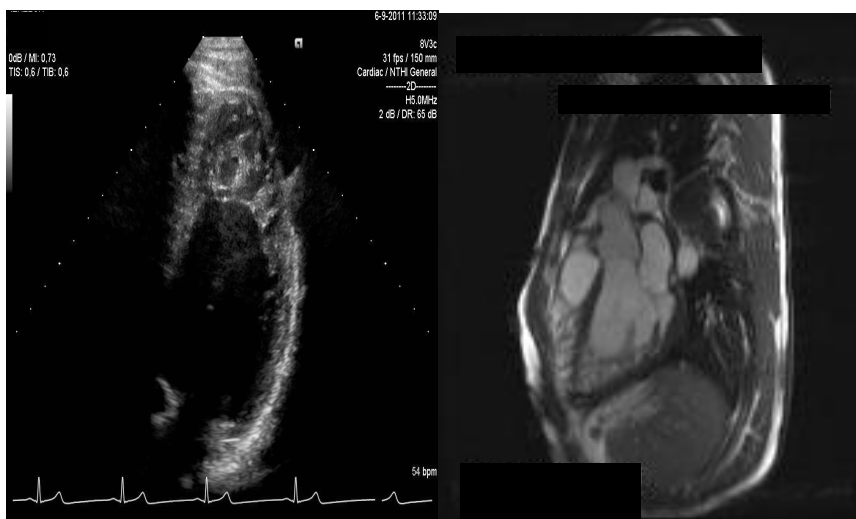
Close view of 4-chamber echocardiographic and 3-chamber MRI view of a 25 years old asymptomatic son of a female who was firstly presented in 2010 with paroxysmal atrial fibrillation and heart failure due to severe LV dysfunction at an age of 58 years. At the MRI, he had an ejection fraction around 40 % and prophylactically treated with an angiotensin-converting enzyme inhibitor and a beta-blocker.
